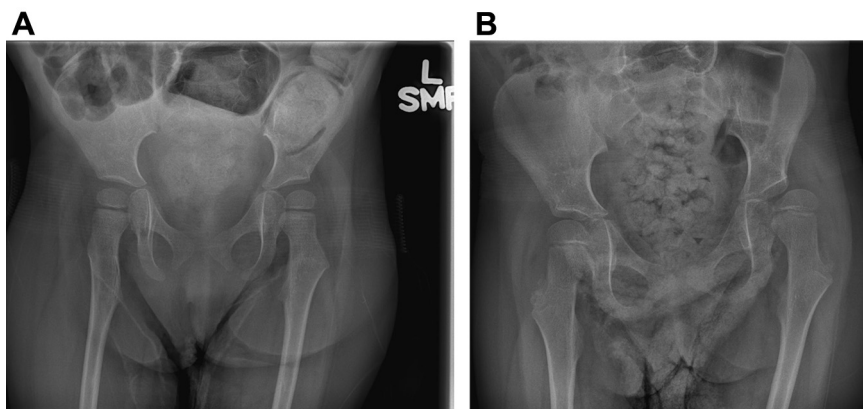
Progression of hip displacement in a child with Growth Motor Function Classification System level V cerebral palsy. (A) Pelvis radiograph at 3 years of age showing both femoral heads well covered under the acetabulum. (B) Pelvis radiograph at 5 years of age showing left hip subluxation.
